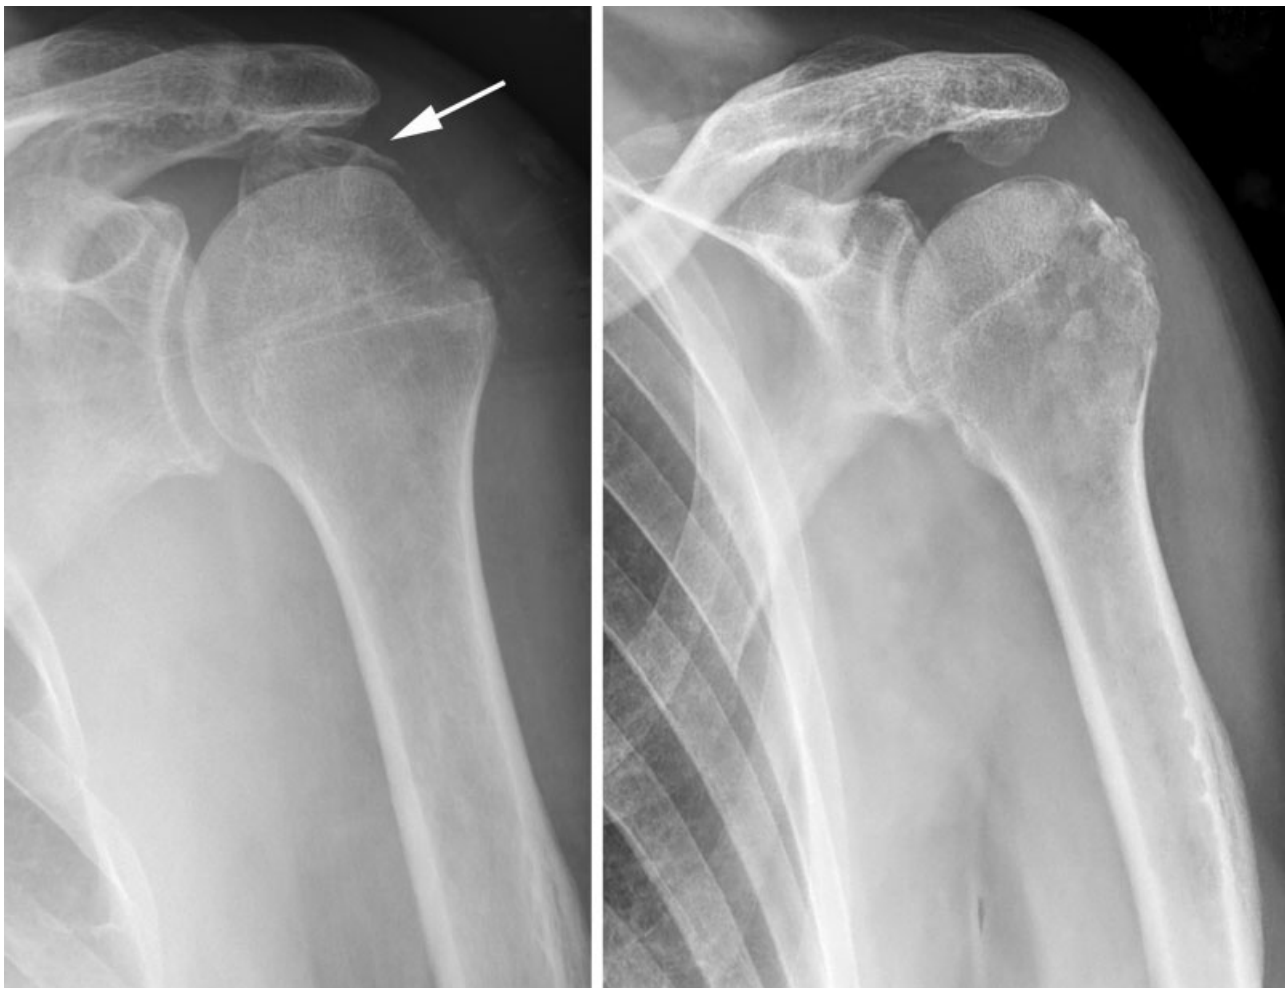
Preoperative and postoperative X-rays showing the initial displacement and the final result in one case.
